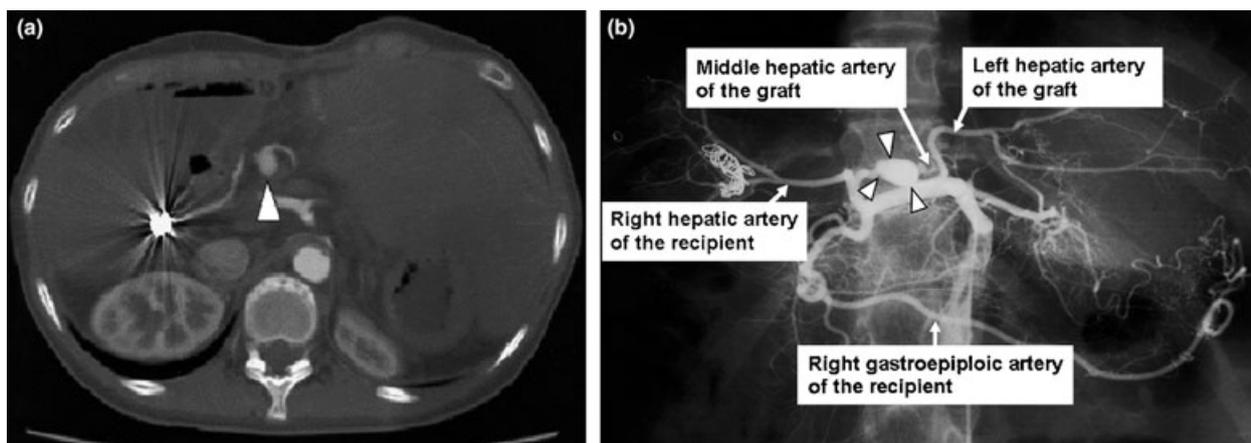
(a) Abdominal computed tomography examination 4 years after auxiliary partial orthotopic liver transplantation (APOLT). Arrow head indicates the aneurysm at the interposition vein graft site. (b) Celiac angiography 4 years after APOLT. Arrow head indicates the aneurysm at the interposition vein graft site. Note the relatively large right gastroduodenal artery.
